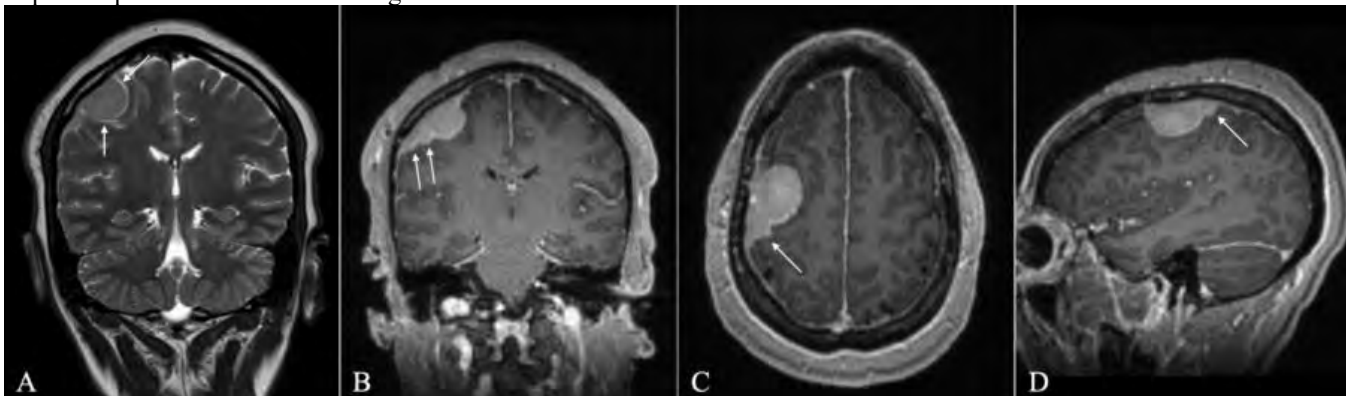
(a) Coronal T2-weighted SE image demonstrates the classic appearance of an extra-axial mass with "CSF Cleft" sign (arrows). (b-d) Coronal, axial, and sagittal contrast-enhanced 3D T1-weighted GRE images demonstrate a multi-lobulated and somewhat irregular (arrows) extra-axial dural-based mass lesion with an impression and mass effect upon the underlying right frontal high convexity.
